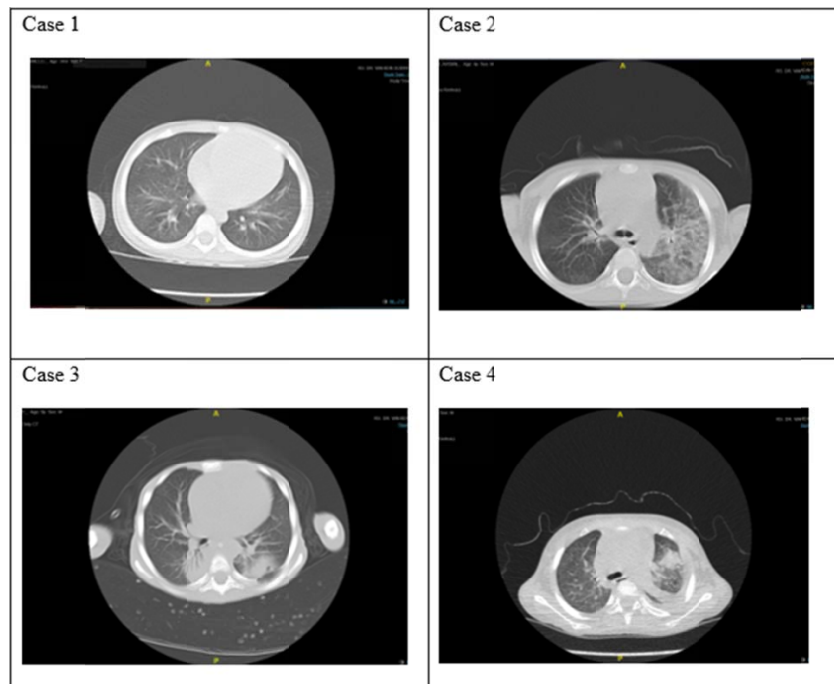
CT images of the four patients on diagnosed as SARS-CoV-2 infection
